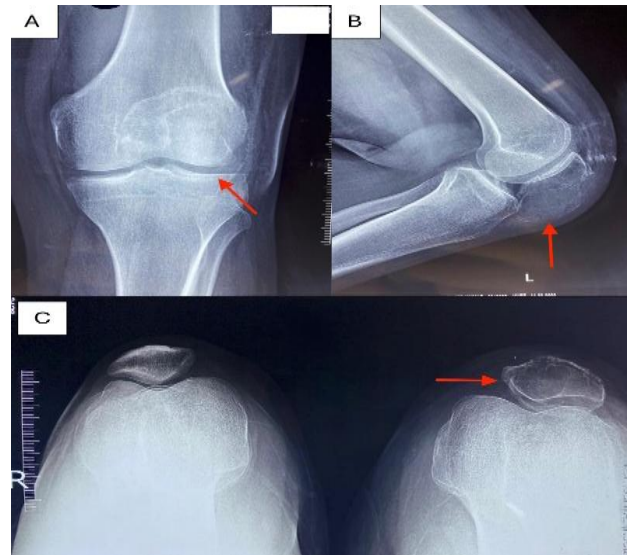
Radiographs obtained after a 3-month interval: (A) anteroposterior and (B) lateral views demonstrating interval progression with inferior extension beyond the patella toward the patellar tendon/adjacent soft tissues, and (C) skyline view showing preserved articular margins and an intact anterior cortical outline.
